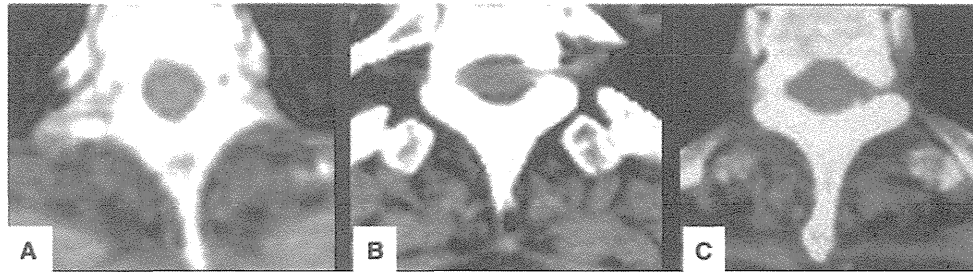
Muscle CT images of AMA-positive patients with the symptoms of weakness in neck flexion and lordotic posture. Paravertebral muscles at the upper thoracic level showed muscle atrophy and fatty changes in Patient 5 (A), Patient 7 (B) and Patient 23 (C).
